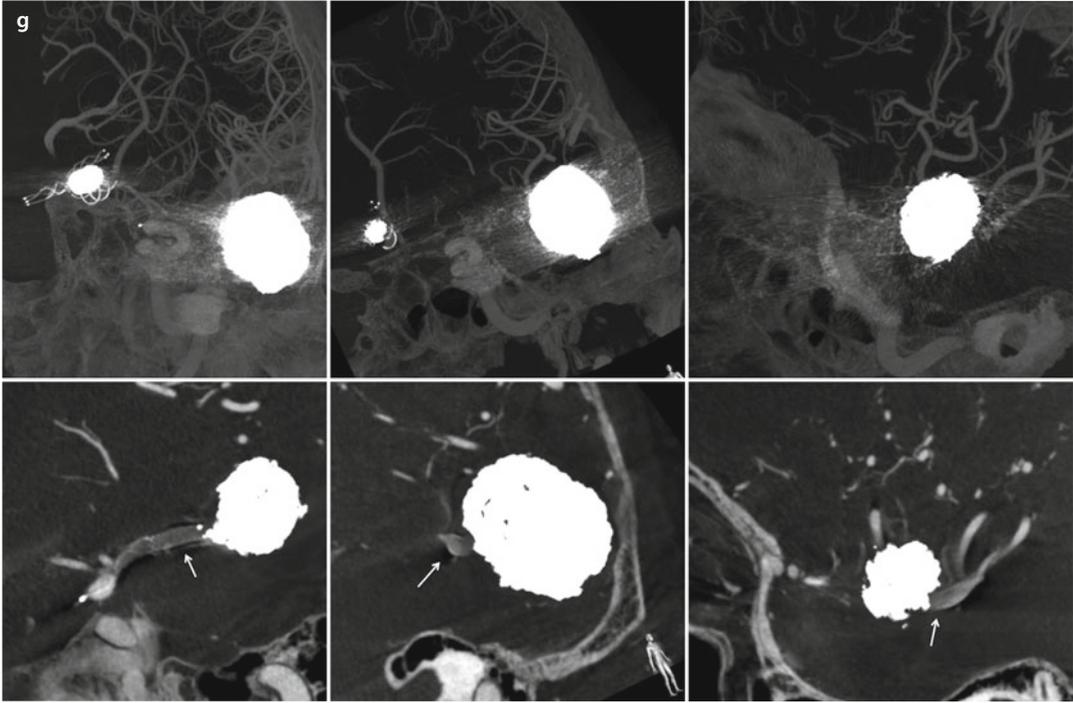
(continued) (g) IA VASO CT® Image Panel. Upper row: M1, MCA bifurcation, and M2 segments are hidden by metal artifact from the coils, pCONus® (Phenox GmbH, Bochum, Germany) and PED® devices. Lower row: Post-FDCT metal artifact reduction (MAR) algorithm images reveal the formerly non-visualized M1 segment, proximal lower trunk, and distal lower trunk of MCA that are stented with PED® (*arrow*)
